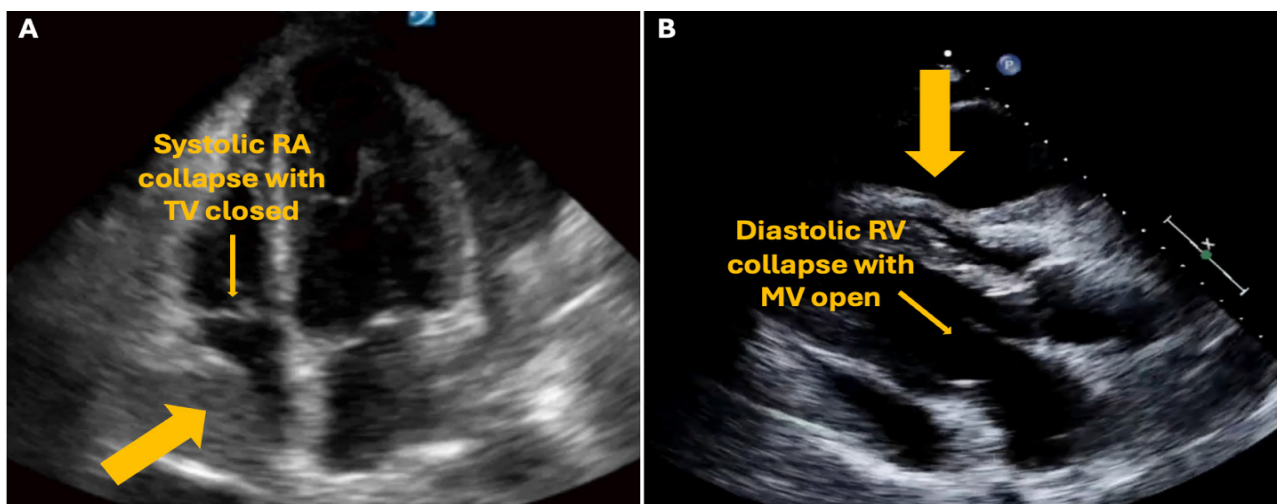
Echocardiographic evidence of right atrial collapse during systole, when the atrioventricular valves are closed, which is an early and sensitive but nonspecific sign of cardiac tamponade (A), and right ventricular diastolic collapse, which is more specific for tamponade physiology (B).
